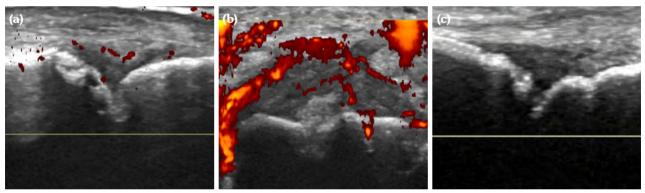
Power Doppler ultrasound images of SNRA, SPRA and non-RA. (a) A-51-year-old female patient diagnosed with SNRA; power Doppler ultrasound showed Level 2 blood flow signal; (b) a 49-year-old female patient diagnosed with SPRA; power Doppler ultrasound showed Level 3 blood flow signal; (c) a 72-year-old female patient diagnosed with osteoarthritis; power Doppler ultrasound showed Level 0 blood flow signal.
